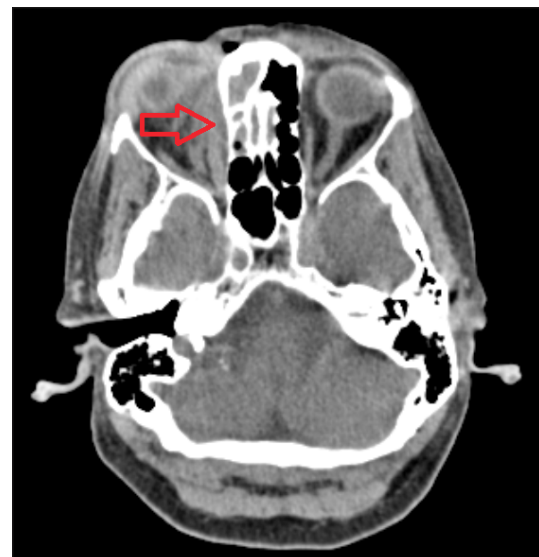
Axial non-contrast CT of the orbits and ethmoid sinus. Proptosis and inflammation of the soft tissue in the medial wall is seen with an arrow pointing to the sub-periosteal abscess. Inflammation of the right ethmoid sinuses is also apparent.
